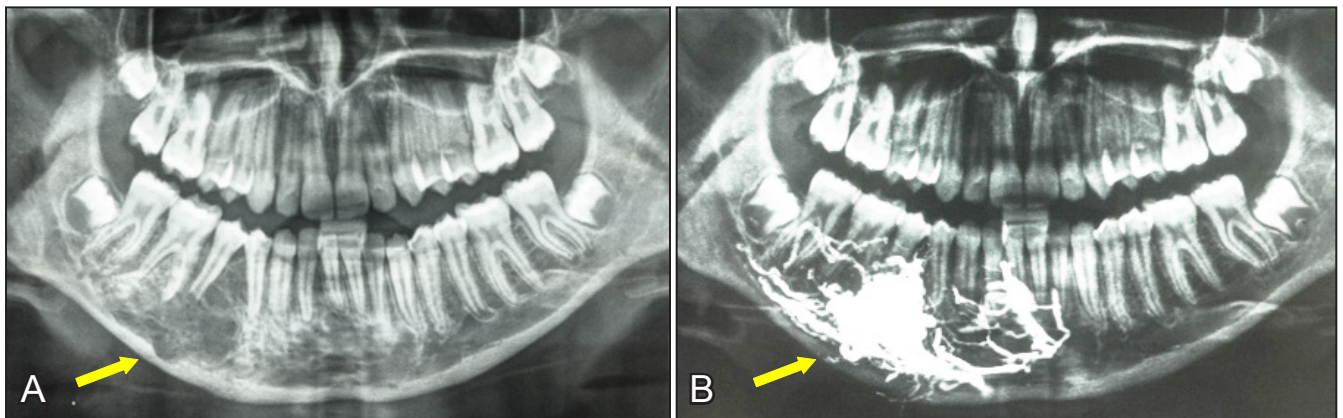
A = initial orthopantomogram of the patient number 4, showing an extended, ill-defined IVA at the right mandibular body; B = orthopantomogram of the same patient, directly after embolization with Onyx®, showing compact lodgement of the embolic agent in the varix.
